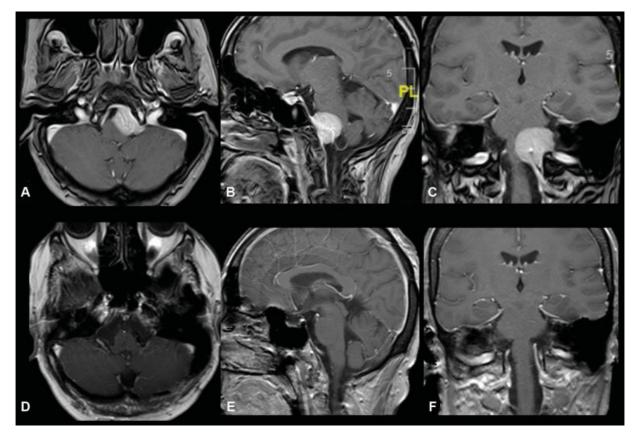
Preoperative T1-weighted postcontrast axial (A), sagittal (B), and coronal (C) MR images of a 50-year-old female patient, demonstrating a diffusely enhancing mass lesion originating from the left lower clival region. (D–F) Postoperative MR images of the same patient, demonstrating gross total resection of the tumor. MR, magnetic resonance.
